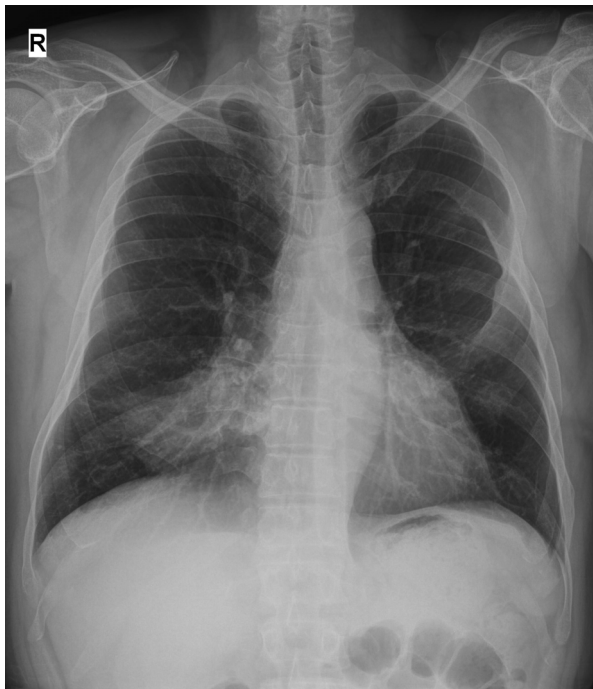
Chest radiograph shows focal infiltration in the right middle lobe.
